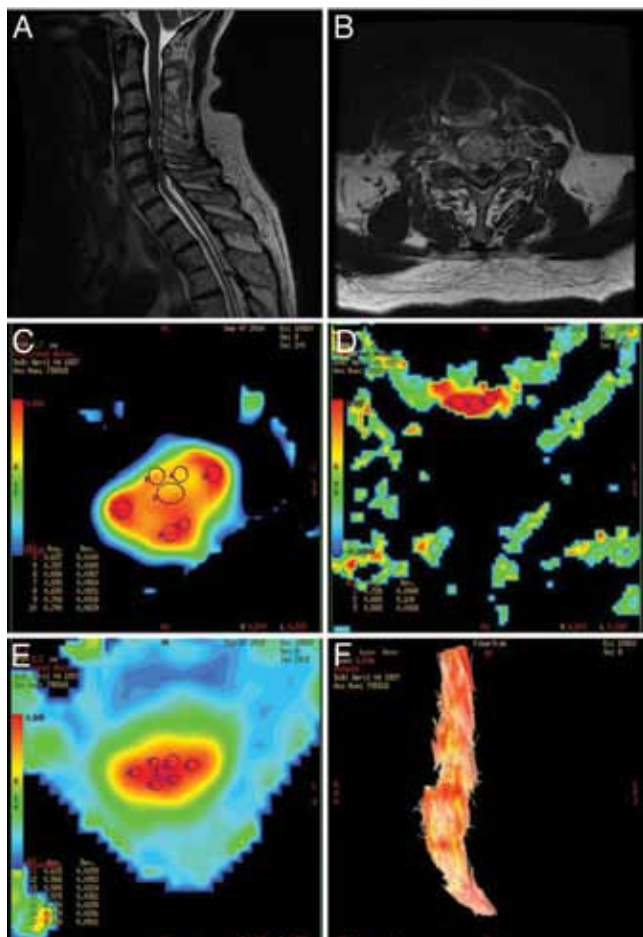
The T2-weighted MR imaging studies of the cervical spine demonstrate a mass-like OPLL posterior to the C-6 and C-7 VBs (A), and deformation of the spinal cord (B). The FA values from the region of stenosis (D) are relatively preserved in comparison with C2–3 (C) and C7–T1 (E) levels. The fiber tracking is also robust (F).
